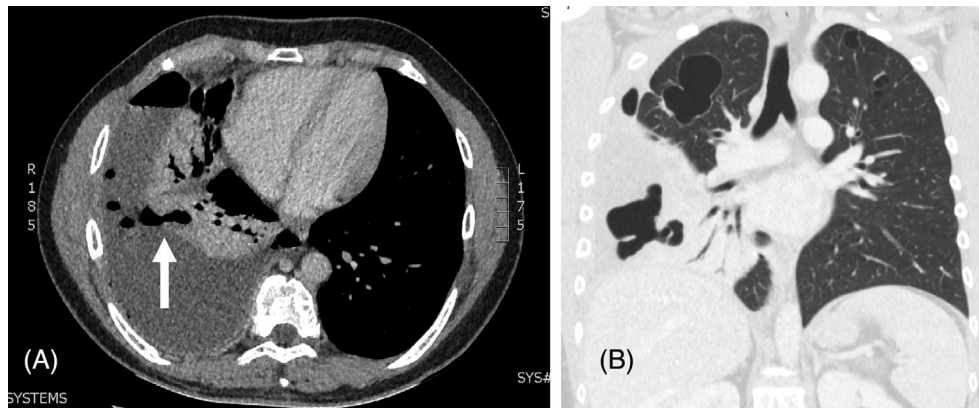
(A) Chest computed tomography scan performed on the day of admission showed a large hydropneumothorax. A breach of the visceral pleura was seen with direct communication between the lung cavity/pneumatocele and the pleural space (arrow). Air bubbles were within pleural fluid suggested multiple localizations. (B) The coronal view showed bilateral longstanding pneumatoceles.
